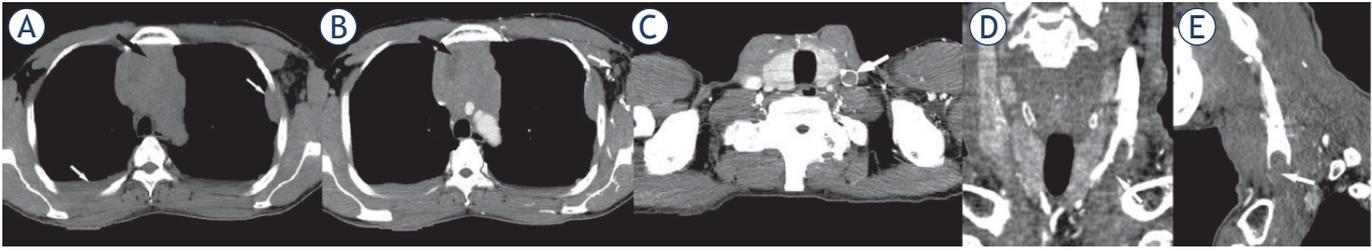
A 47-year-old man with PTCL in the anterior mediastinum. (A) Axial non-contrast CT image shows an ill-defined, irregular mass with inhomogeneous density in the anterior mediastinum (black arrow). Multiple pleural metastases are detected (white arrows). (B) Contrast-enhanced CT image shows the tumor with heterogeneously mild enhancement. Intratumoral necrosis is seen in the mass (black arrow). Lymphadenopathy is seen in the left axillary fossa (white arrows). (C, D, E) The left internal jugular vein is invaded by the tumor and vessel occlusion is detected on contrast-enhanced CT image and MPR images (white arrows). Tumor progression was found during therapy. This patient deceased at 3 months after therapy.
